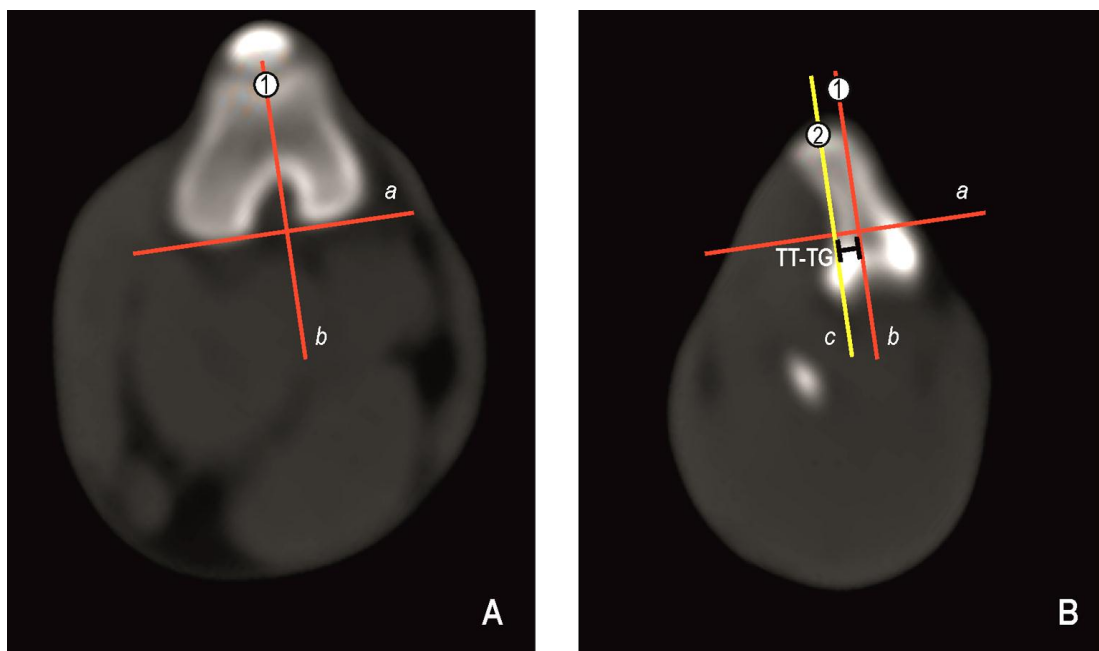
Conventional 2D measurement of the TT-TG distance: (A) The CT section through the trochlea (section 1) and the CT through the tibial tuberosity (section 2) are aligned with section 1 brought in front. A line joining the posterior femoral condyles is drawn (reference red line a). A perpendicular to the reference line (red line b) is then dropped through the deepest point of the trochlear groove (landmark 1). (B) Section 2 is brought in front and a second perpendicular (yellow line c) is dropped to the reference line through the most anterior point of the tibial tuberosity (landmark 2). The distance between the two perpendiculars is measured as the tibial tuberosity - trochlear groove distance (TT-TG).
